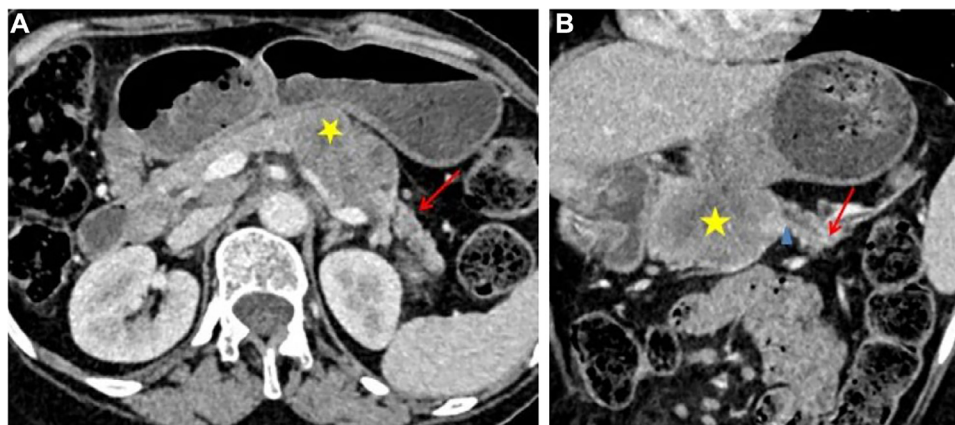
Abdominal CT scan with pancreatic arterial phase injection, in axial (Fig. A) and coronal (Fig. B) sections, revealing a heterogeneous tissue mass in the body of the pancreas measuring 4 cm in greatest diameter (yellow star). Associated findings include atrophy of the upstream tail (red arrow) and ectasia of the distal Wirsung duct (blue red arrow head).
